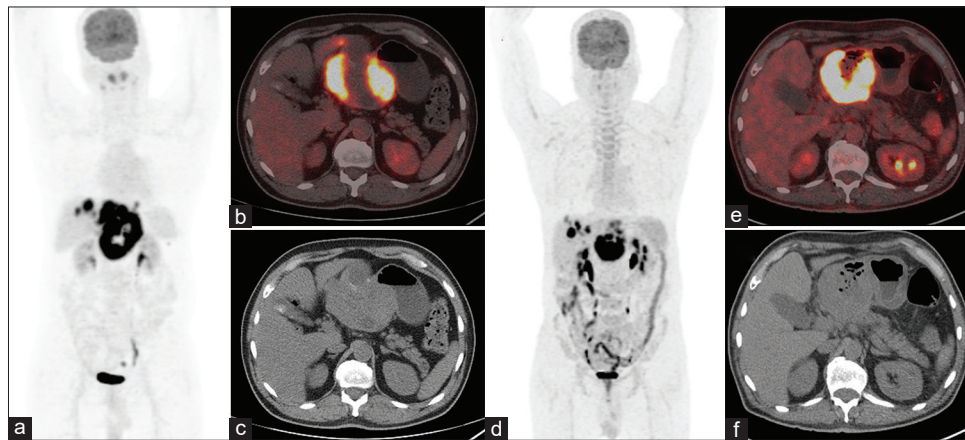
Case of 63-year-old male who underwent baseline 18F-FDG Positron emission tomography/computed tomography (MIP [a], Trans-axial Positron emission tomography/computed tomography [b], Trans-axial computed tomography [c]) for Gastro Intestinal Stromal Tumor, which revealed metabolically active primary disease in the pylorus, with metastases to the liver. The patient underwent follow-up Positron emission tomography/computed tomography after 4 months (MIP [d], Trans-axial Positron emission tomography/computed tomography [e], Trans-axial computed tomography [f]), which revealed reduction in the size and metabolic activity of the primary and the liver lesions, which was suggestive of partial response
